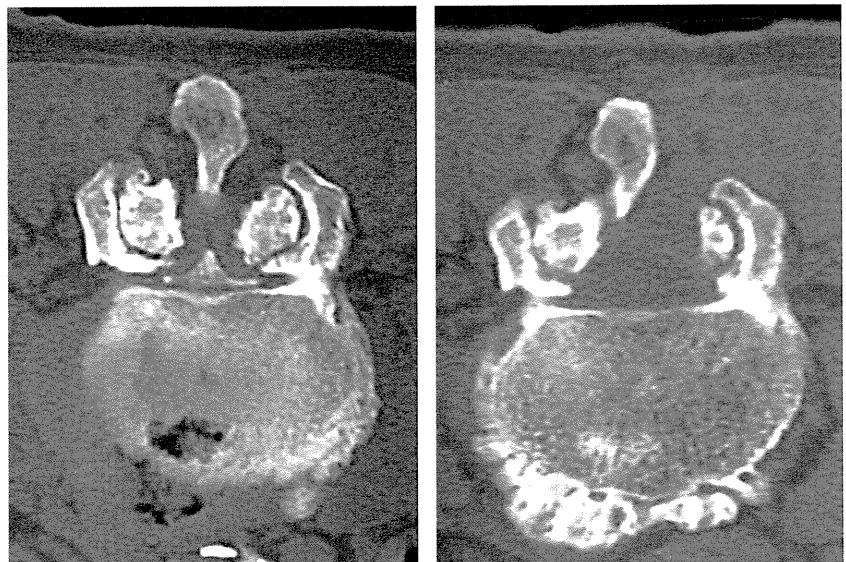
CT myelogram before operation and CT after operation. The lumbar spinal canal was adequately decompressed on the side of approach as well as the contralateral side.
